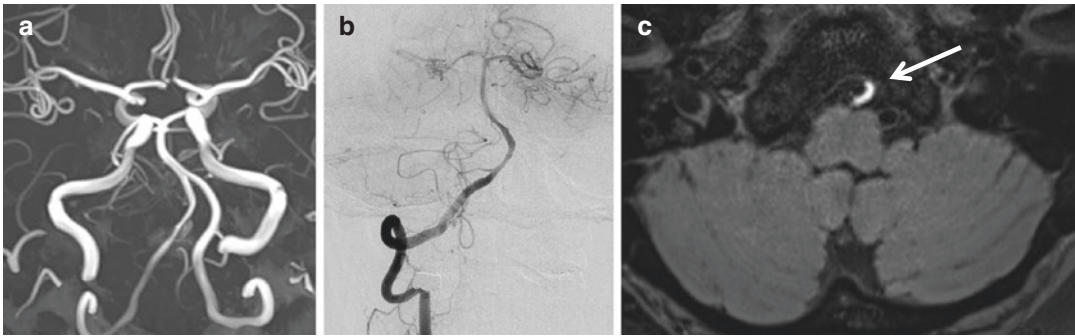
A 47-year-old, previously healthy man suddenly developed severe right occipito-nuchal headache. MRI findings were normal. MRA (a) and conventional angiogram (b) showed suspicious narrowing of the right
